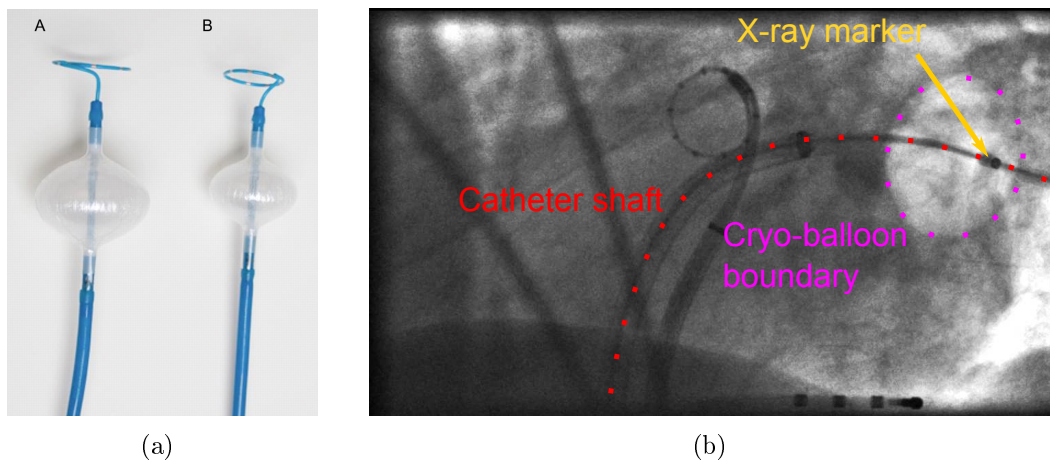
(a) Cryoballoon catheters of different sizes with an Achieve mapping catheter (Medtronic, Minneapolis, USA). Image courtesy by [Chie 12], Oxford university press. (b) A cryoballoon catheter as seen under X-ray. A previous approach for cryoballoon reconstruction [Klei 11] involves manual annotation of the balloon boundary (dotted, magenta). We propose two new methods for automatic reconstruction: in the appearance based approach, the X-ray marker (yellow arrow) is found first followed by a detection of the balloon boundary. The automatically detected balloon boundary replaces the manual annotation of the previous reconstruction approach. The second, model-based approach uses the automatically detected X-ray marker for detection of the catheter shaft (dashed, red). After 3-D reconstruction of both the X-ray marker and the catheter shaft, the 3-D centre of the balloon is found using prior knowledge regarding the catheter model used during the procedure.
